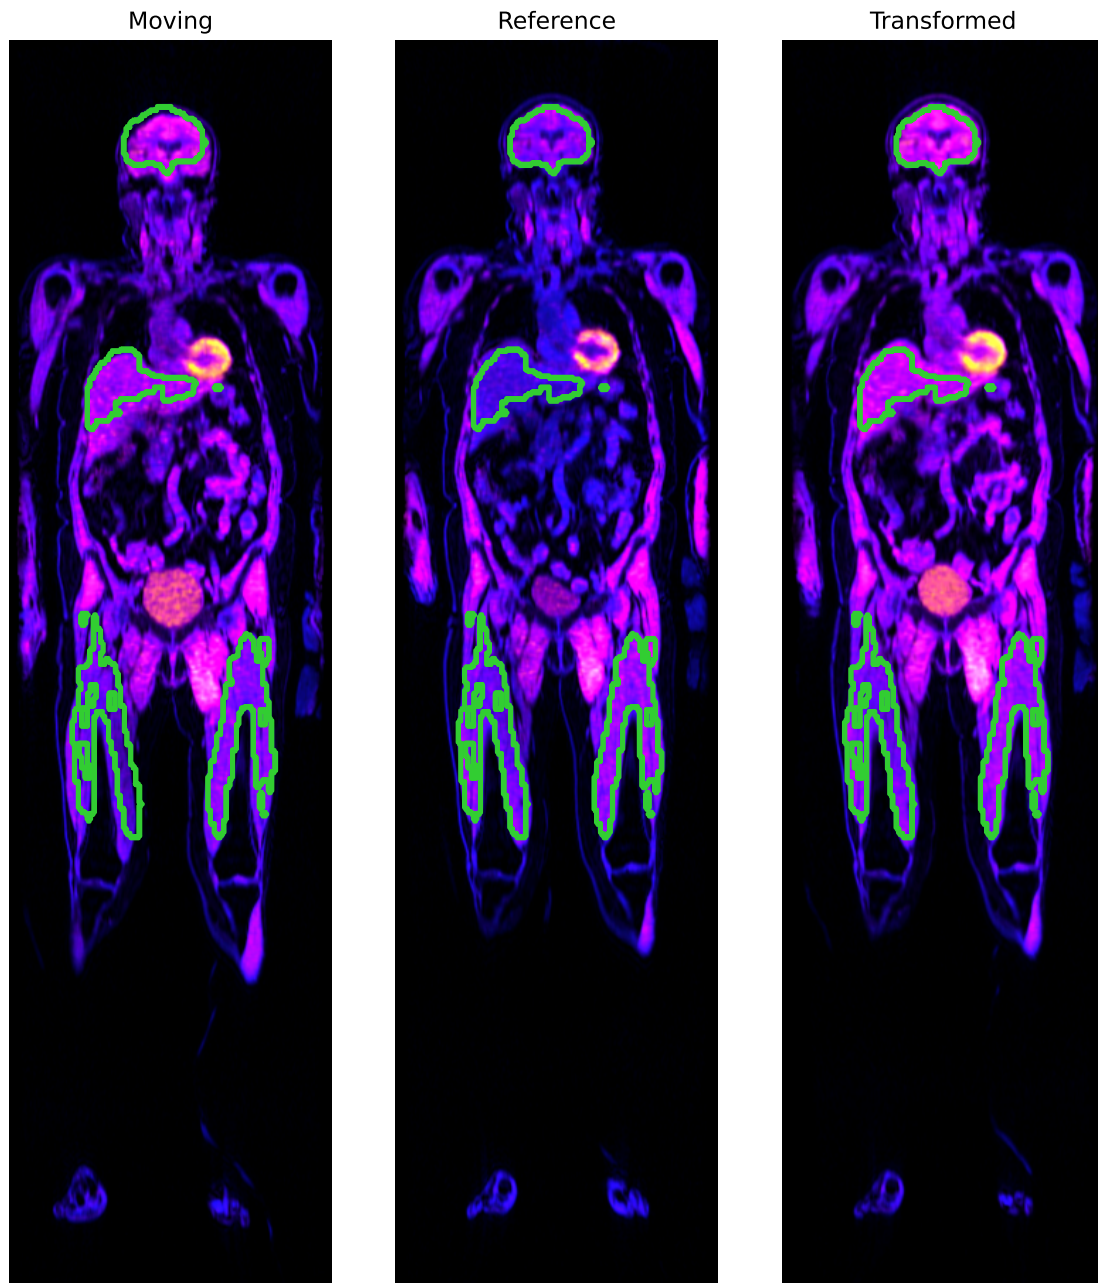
Fused PET/MR images, of a representative slice of a 3D volume, with marked segmentations for brain, liver, lquad and rquad, for the moving, reference and transformed image.
